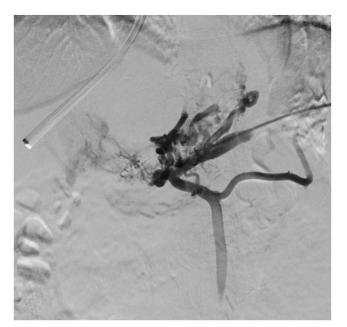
Initial splenic venogram via direct splenic venous access before PVR and TIPS placement confirms the CT findings of main portal vein occlusion with cavernoma.
